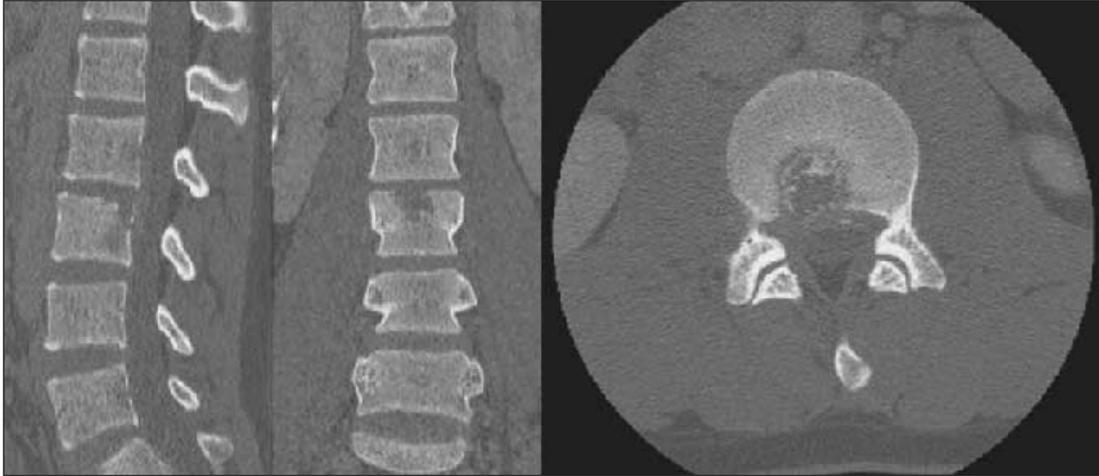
CT scan show extensive bone resorption of the involved level
